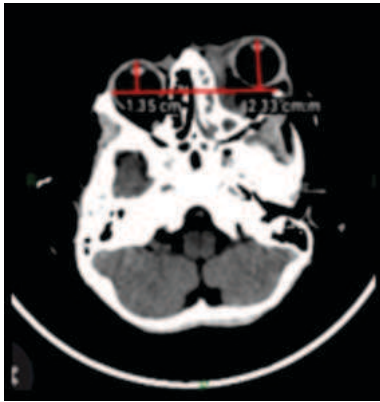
CT Scan Showing Left Eye Proptosis and Left Ethmoid Sinusitis With Left Eye Subperiosteal Abscess
